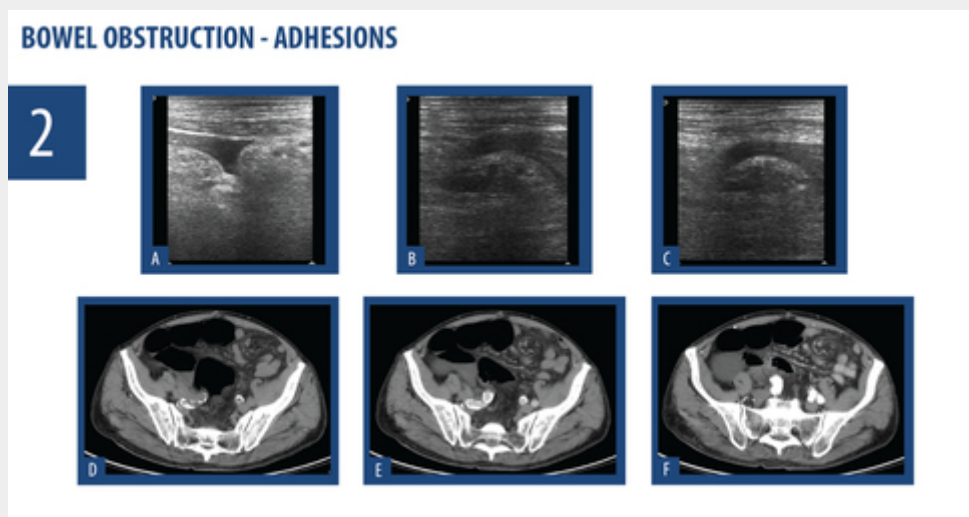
83 year-old patient with a history of partial gastrectomy and subtotal colectomy. He was admitted with diffuse abdominal pain. On US (A,B,C) there was bowel distention and wall thickening. He underwent CT (D,E,F) which demonstrated marked fluid distention of the small bowel. There was an image of mesentery rotation which was attributed to adhesions or bands.
